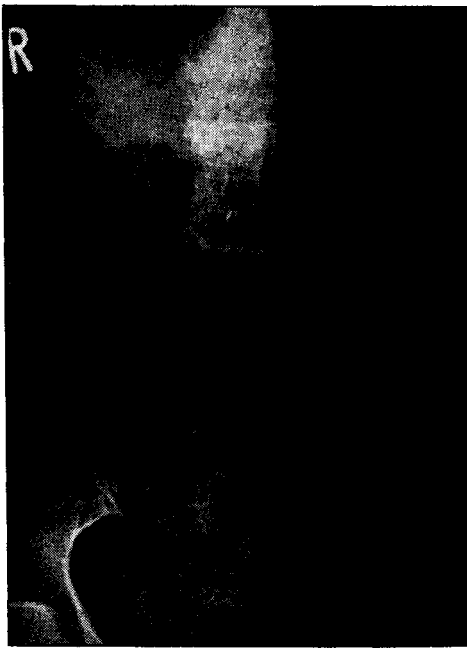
Roentgenologic findings of the lumbar spine. This roentgenogram shows severe osteoporosis and deformity of her lumbar bone.
